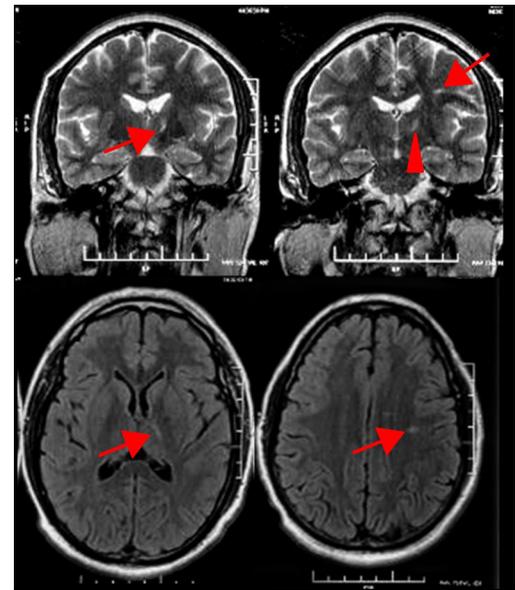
T2/fluid attenuation inversion recovery (FLAIR) hyperintense lesions in the left anterolateral thalamus and left frontal subcortical white matter suggestive of lacunar infarcts.
